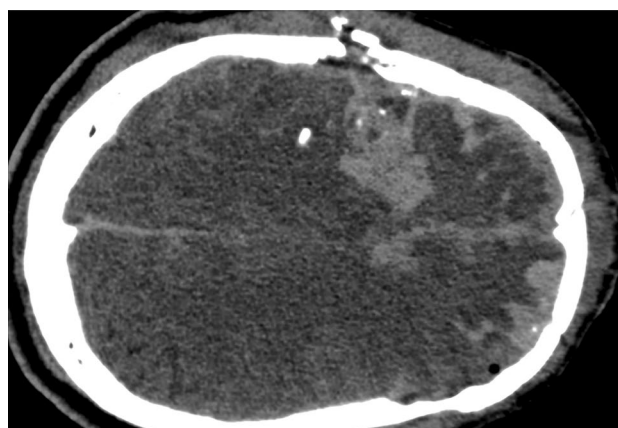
Axial CT image of left temporo-parietal GSW
